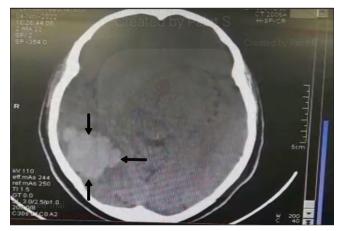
Control noncontrast-enhanced computed tomography scan, parenchymal window: Axial view, 9 months after initial visit. Arrows showing the same hyperdense lesion seen on initial CT scans.
